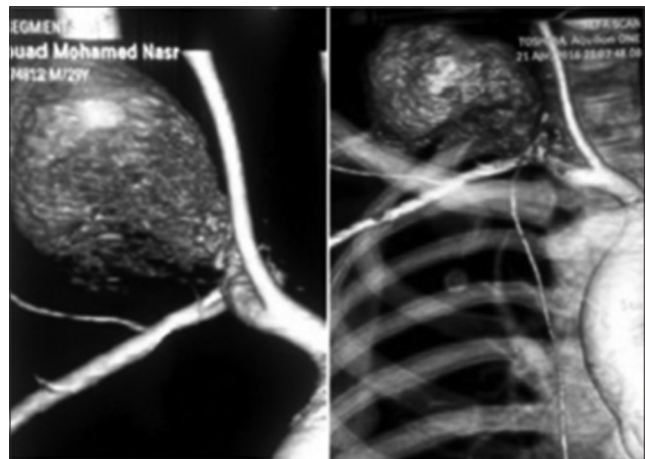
Computed tomographic three-dimensional reconstruction showing a large pseudoaneurysm originating from the first part of the right subclavian artery.
